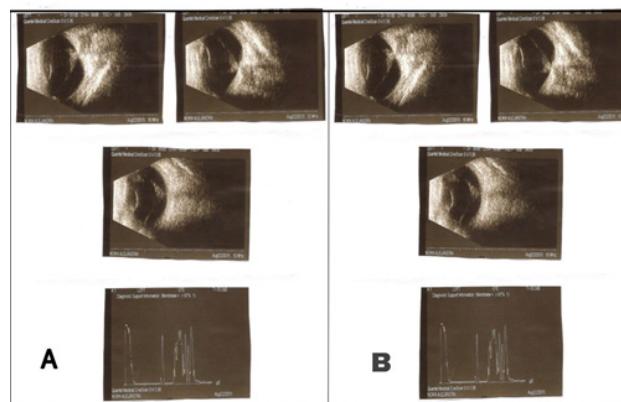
OCULAR ULTRASOUND.
